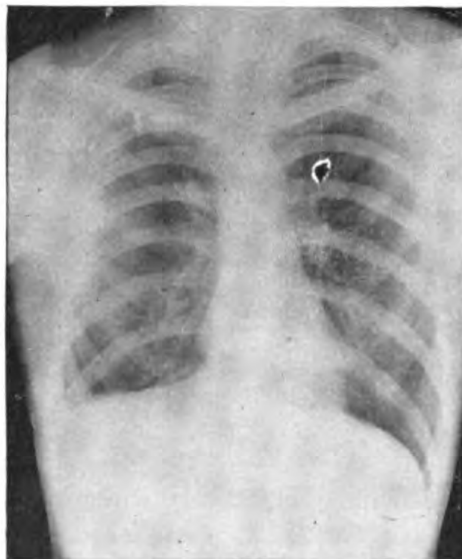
Case 3. Roentgenogram taken 5 weeks after operation. Slight residual pleural thickening is demonstrated.*
